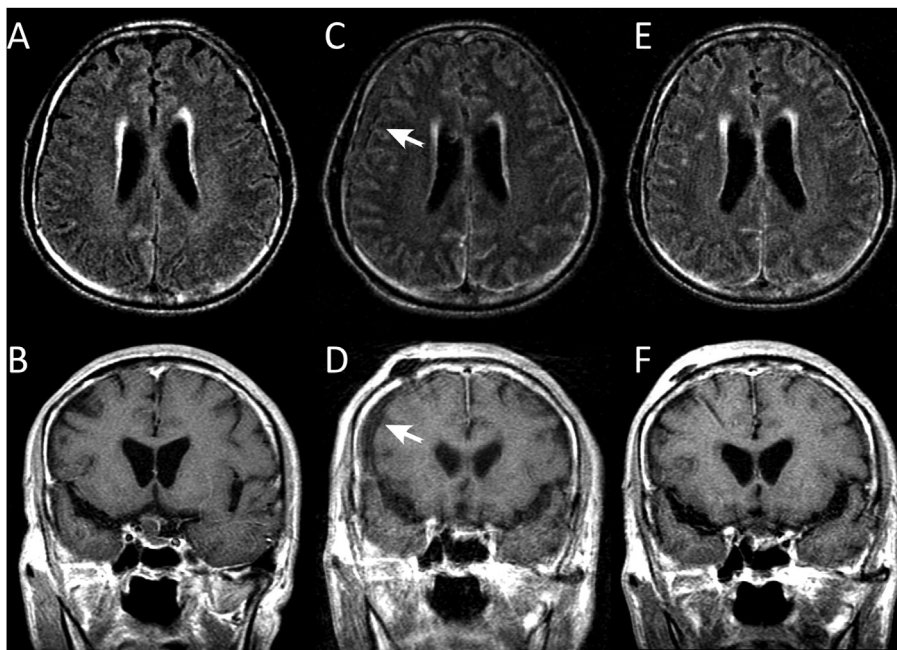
Axial fluid-attenuated inversion-recovery (A, C, E) and T1-weighted (B, D, F) magnetic resonance imaging (MRI) scans of a 55-year-old man with cryptococcal meningitis (Patient 4) at admission (A, B), on treatment with a ventriculoperitoneal shunt (C, D), and after clipping the shunt (E, F). MRI scans on readmission revealed marked ventricular enlargement (A, B). A ventriculoperitoneal (VP) shunt was placed (C, D). However, shunting procedure led to a rapid deterioration of mental status without an obvious decrease in the ventricular size, as measured by repeat MRI 4 days postoperatively. Brain imaging also revealed a thin layer of subdural effusion in the right cerebrum (arrow), indicating CSF overdrainage. After clipping the VP shunt, the patient immediately showed symptom improvement, with regression of the right cerebral subdural effusion (E, F).
